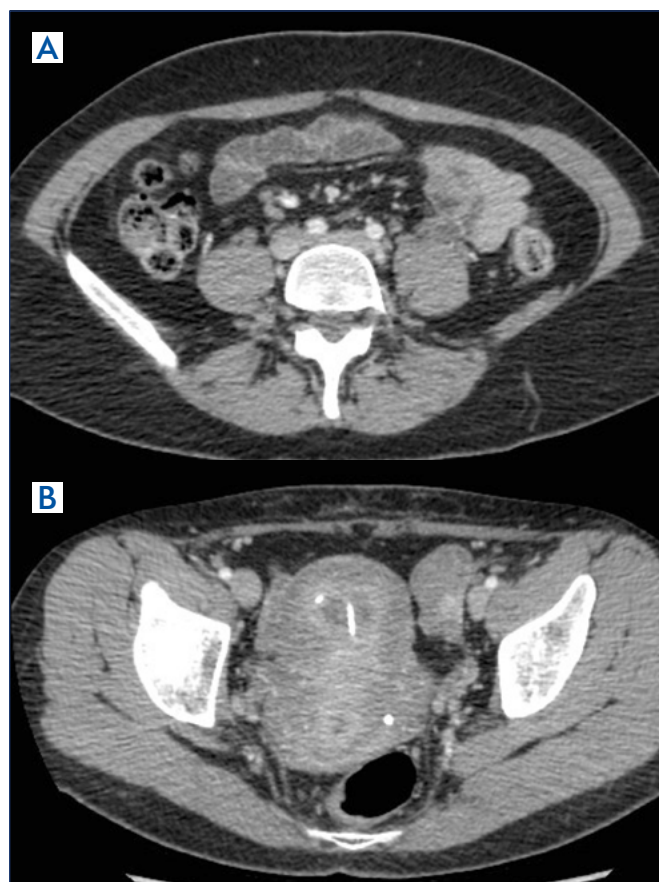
A) Indirect computed tomographic (CT) venography. Left iliac system appears nearly the same as the right. B) Unremitting symptoms prompted us to perform a direct CT venography.
